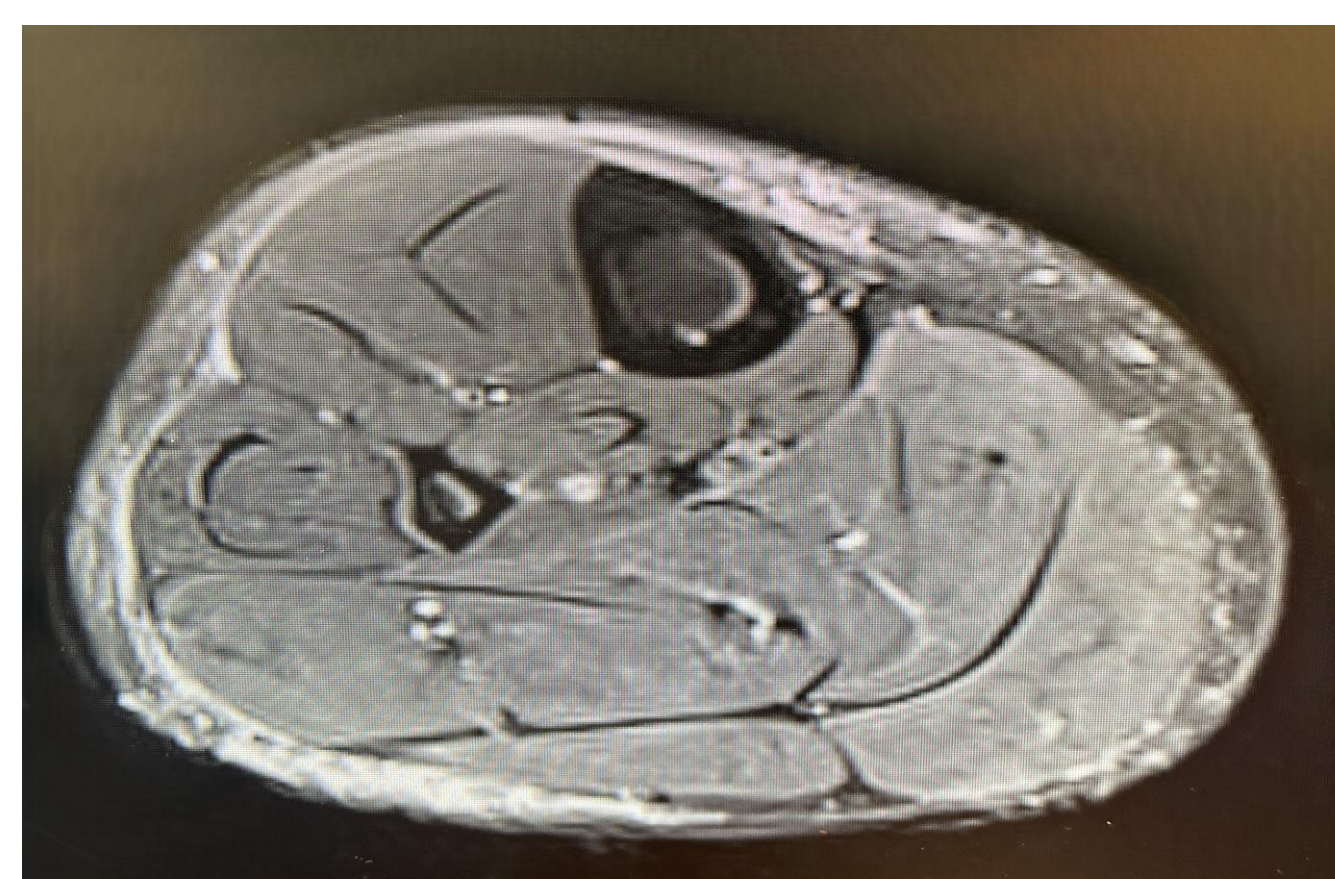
CT Scan Left lower Extremity (3/23)-- Negative
